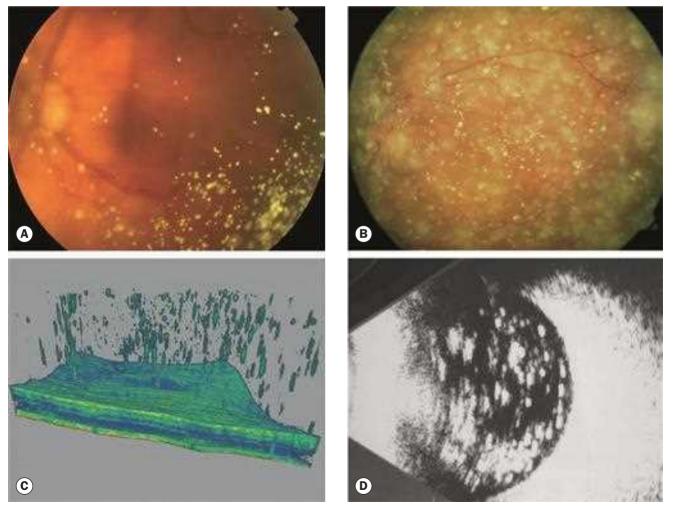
Asteroid hyalosis. (A) Mild; (B) severe; (C) 3-dimensional OCT reconstruction; (D) B-scan ultrasonogram (Courtesy of S Chen – fig. C)
